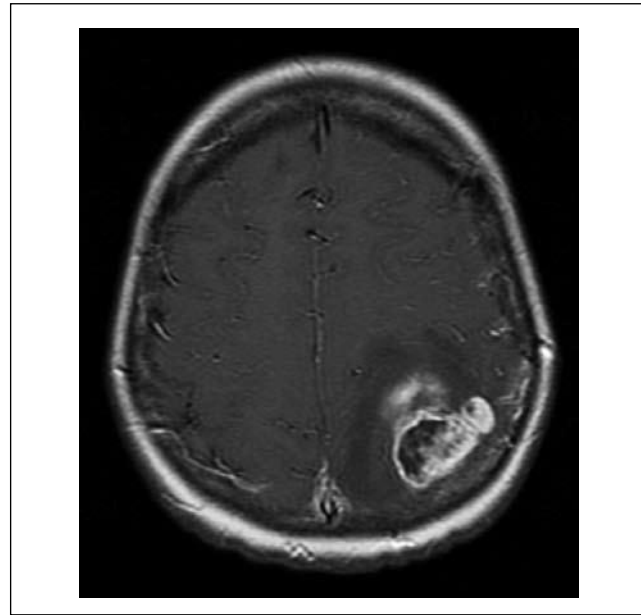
An 18-year-old girl with malignant mesenchymoma of the pelvis and lung metastases. Very severe headache of sudden onset on the day of the examination. MRI, SE/T1-weighted image after gadolinium administration. MRI diagnosis – brain metastasis. Strong contrast enhancement of the lesion, the surrounding oedema is not enhanced.
